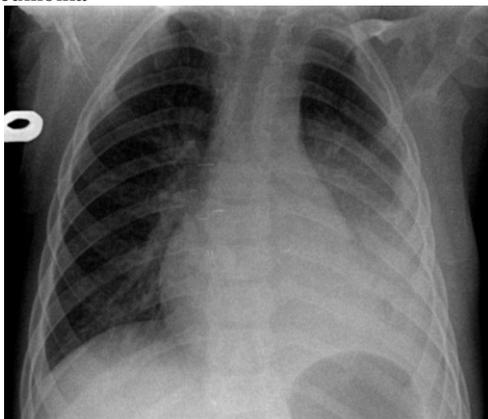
Anteroposterior chest radiograph shows left-sided lower lobe pneumonia. A parapneumonic effusion is also noted
